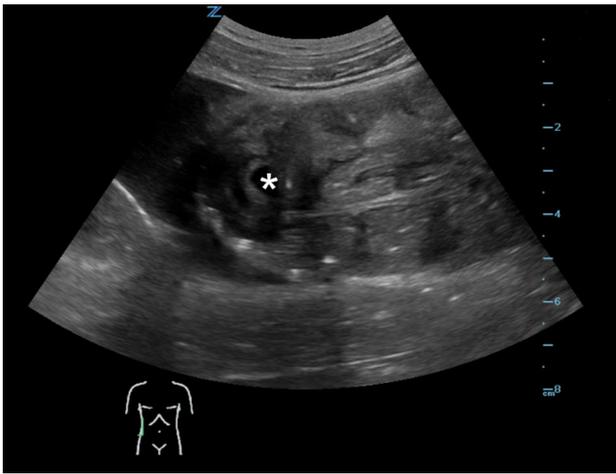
Ultrasound image showing a cystic structure (asterisk) within the intussusception which was thought to be a Meckel diverticulum
